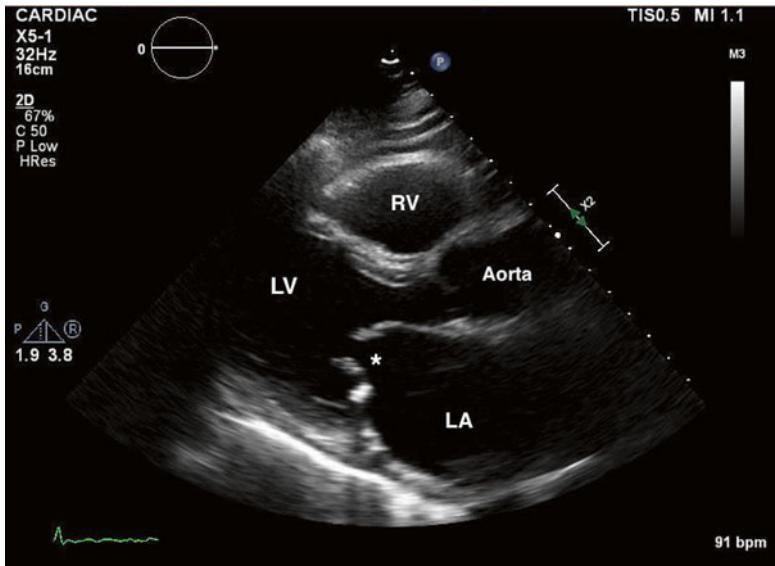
Parasternal long-axis view. Mitral annular calcification with thickened mitral valve leaflets (asterisk) and restricted end-diastolic leaflet excursion. Morphology characteristics suggestive of Rheumatic mitral valve disease. Left ventricle (LV). Right ventricle (RV). Left atrium (LA). Base of the aorta/aortic root (Aorta)
